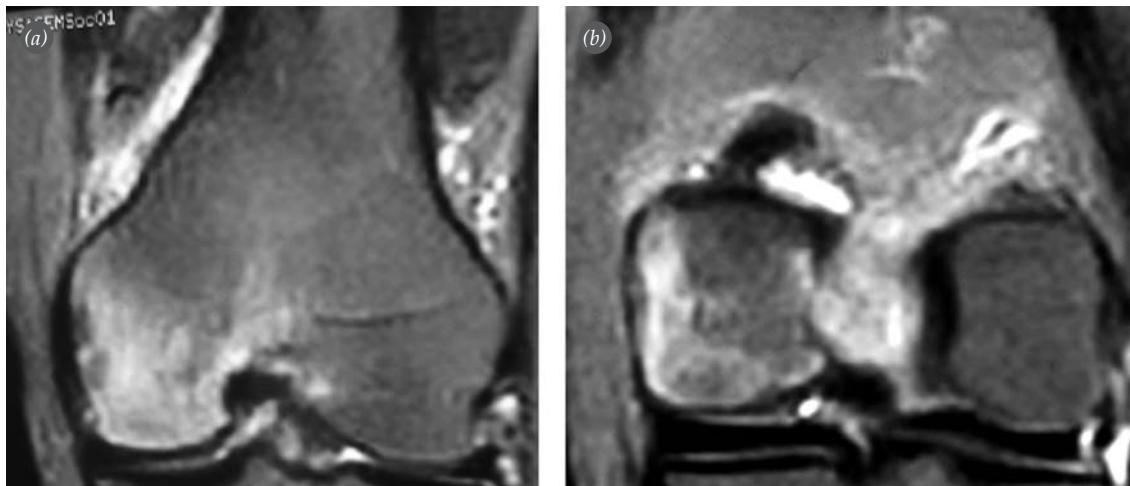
(a) Coronal short-tau inversion recovery (STIR) and (b) transverse MR image showing bone marrow edema in the medial femoral condyle.
